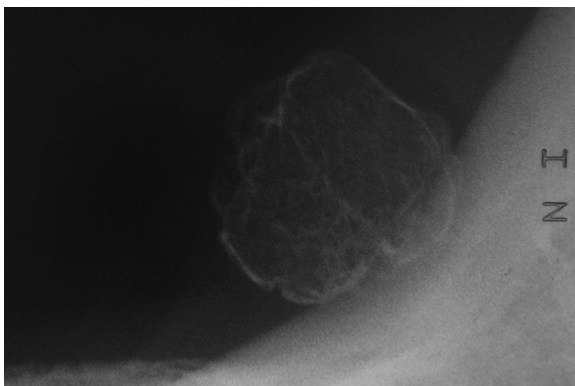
Radiographic aspects of oral osteolipoma. Radiography revealed a spherical radiopacity with an irregular pattern of trabeculae, and no evidence of cortical abnormality or influence on the surrounding structures was found.
